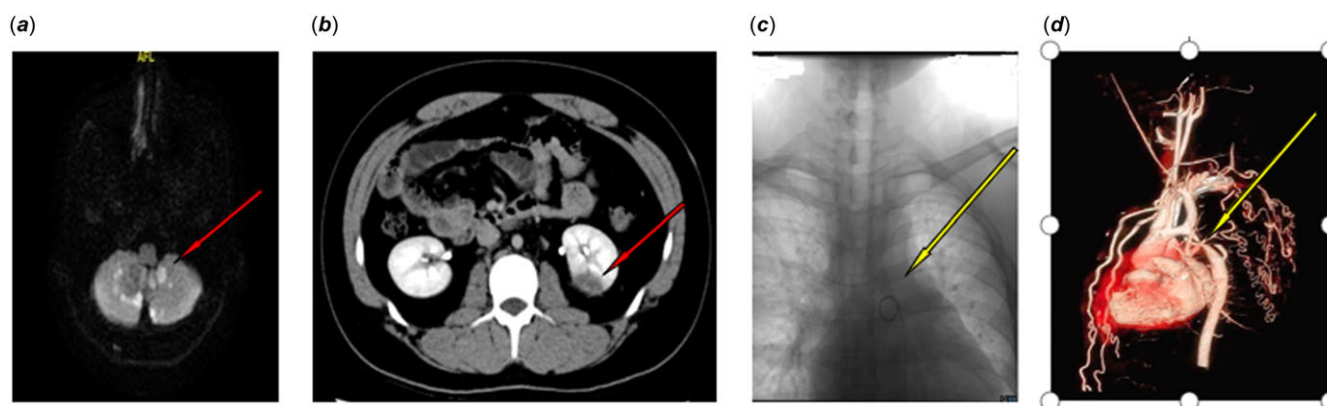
(a) diffusion magnetic resonance imaging of the brain shows acute infarction in both cerebellar hemispheres. (b) contrast-enhanced computed tomography reveals abnormal density lesions in the upper abdomen, localized to the inferior pole of the left kidney, indicative of renal infarction. (c) during cerebral angiography, the advancement of a 5F vertebral artery catheter, navigated by a guidewire, was met with substantial resistance at the level of the aortic arch within the descending aorta, impeding catheter progression and suggesting the presence of aortic stenosis. (d) the thoracic aorta CTA reveals a stenosis at the junction of the aortic arch and descending aorta, with a lumen diameter of approximately 3 mm and a stenotic segment length of about 5 mm. The distal portion of the descending aorta appears attenuated. Multiple tortuous collateral vessels are visible in the thoracic wall and mediastinum, originating from the aorta, left subclavian artery, left common carotid artery, and right brachiocephalic trunk.
